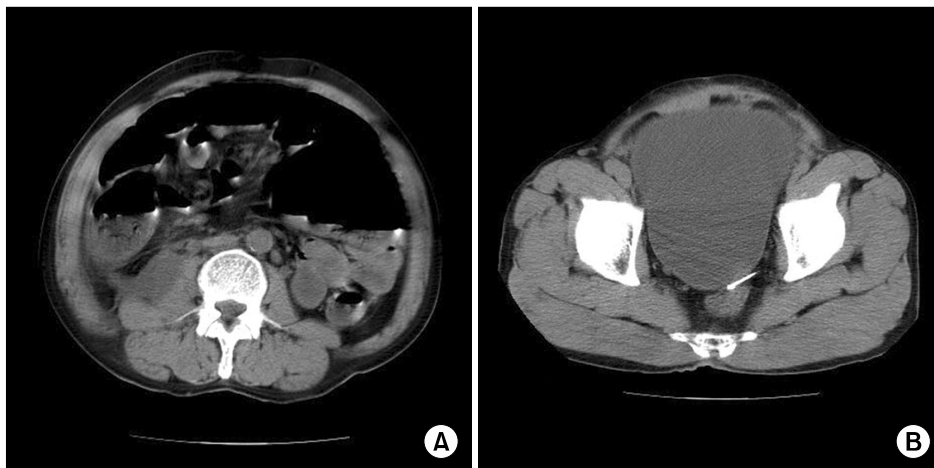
Abdominal computerized tomography (CT). (A) CT was suggestive of a right retroperitoneal abscess, and (B) a needle-like radiopaque lesion between the rectum and bladder.
